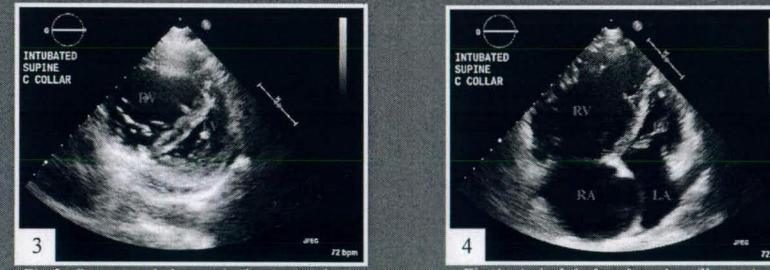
Parasternal short axis demonstrating enlarged RV with septal bowing
